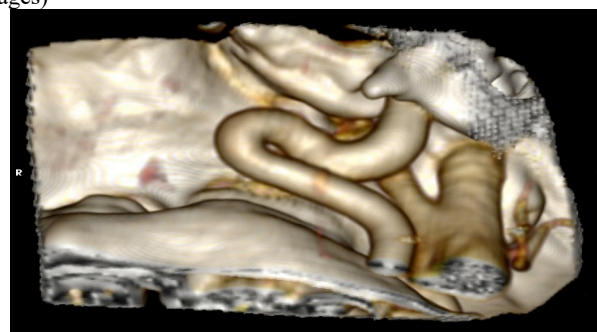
Kinking of the left internal carotid artery cervical segment (3 dimensional reconstruction of computed tomography angiography images)
